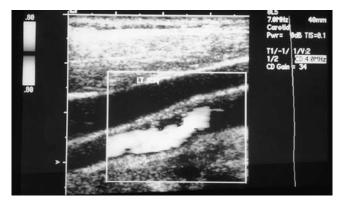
A colour Doppler tracing. Note the isoechoic plaque in the wall, narrowing the lumen.
